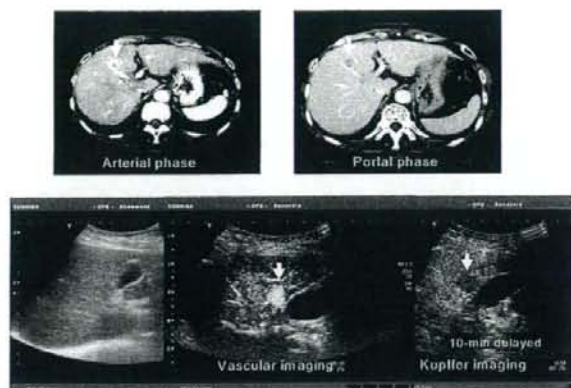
Sonazoid features of HCC. The left top panel shows an arterial phase CT examination of the liver and an enhancing mass in the right lobe. The right top panel shows a wash out on portal phase. This lesion is hardly detected at the B-mode image (left bottom panel). The middle bottom panel shows vascular imaging 30 seconds after intravenous injection of Sonazoid. The tumor is clearly detected as a hyperchoic lesion. The right bottom panel shows Kupffer imaging of Sonazoid and the tumor is detected as an anechoic lesion
